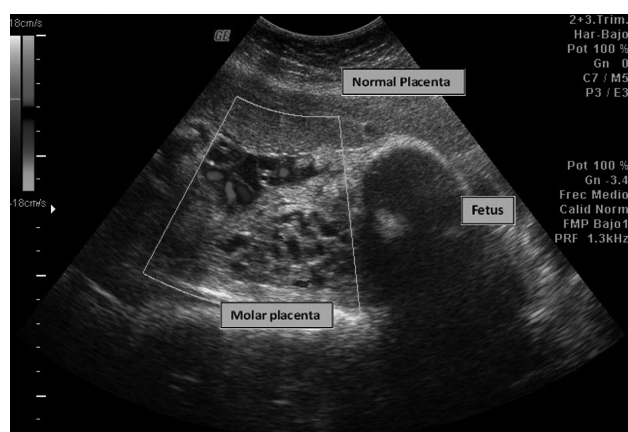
Ultrasound showing fetus, normal placenta, and molar placenta on the posterior uterine wall.
